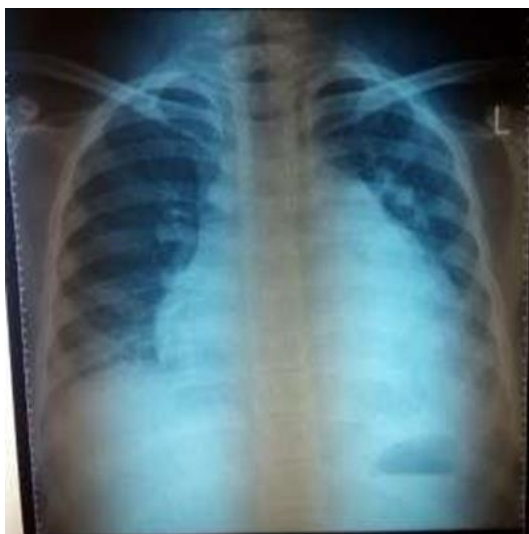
X-ray imaging posteroanterior.
